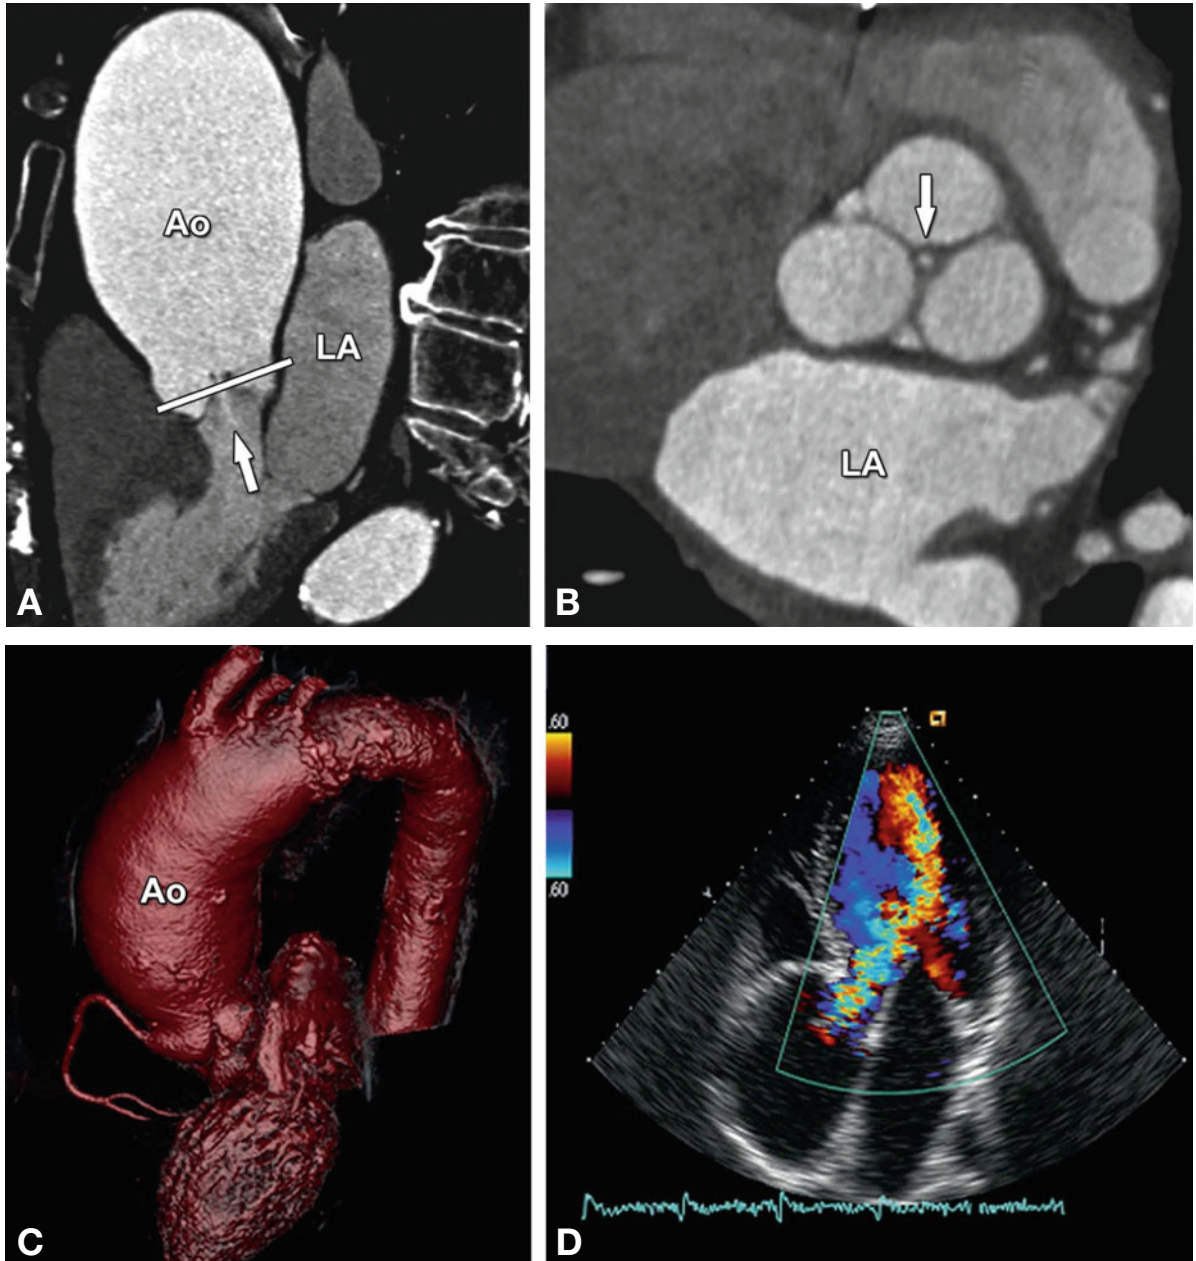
Aortic regurgitation due to ascending aortic (Ao) aneurysm. The three-chamber view (Panel A) shows incomplete closure of the aortic leaflets during diastole with a regurgitant jet downstream into the left ventricular outflow tract (*arrow*). The *white line* in Panel A indicates the position of the cross-section through the aortic root (Panel B). This cross-section shows central valvular leakage (*arrow*, aortic regurgitant orifice area). The ascending aortic aneurysm is shown in a three-dimensional volume rendering in (Panel C) and the corresponding echocardiography (Panel D) shows a Doppler regurgitation jet (“vena contracta”) towards the left atrium. LA left atrium
